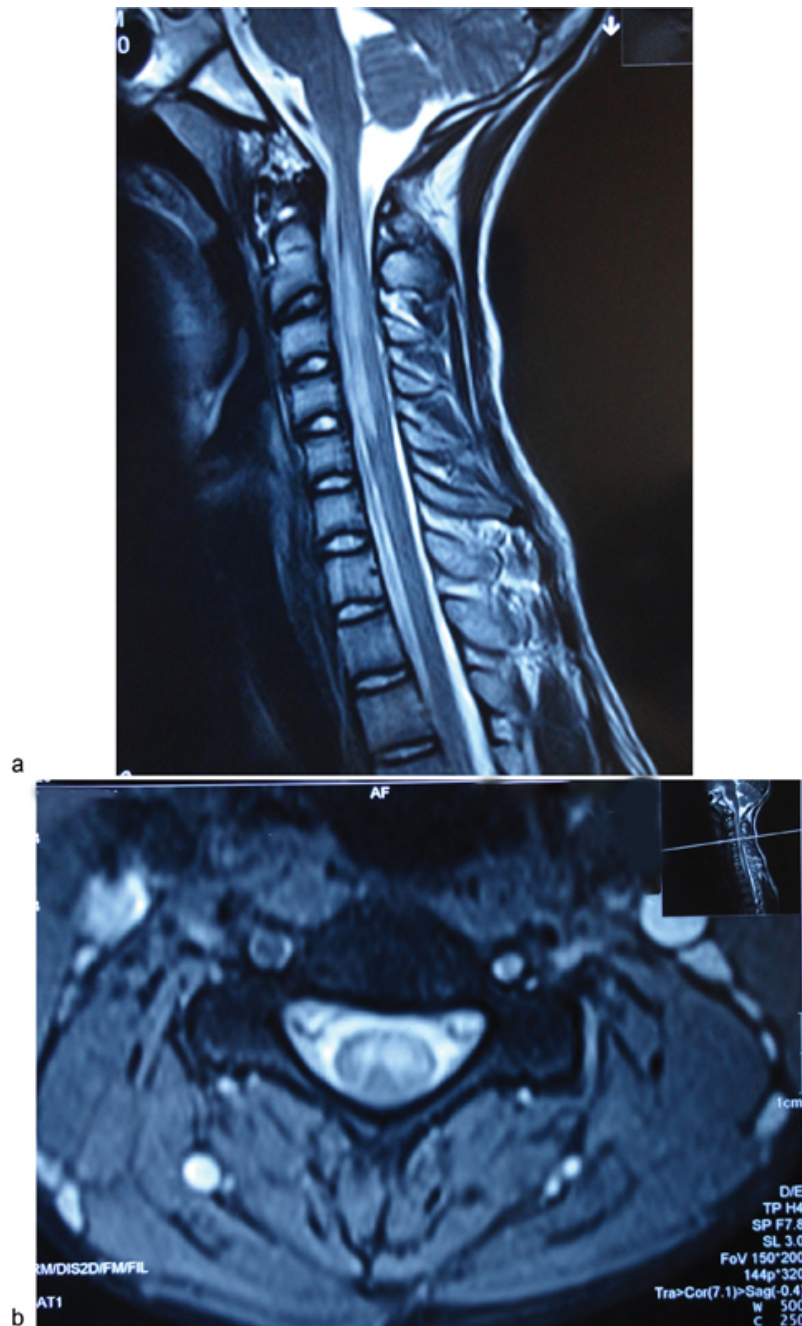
(a) T2 sagittal magnetic resonance imaging (MRI) showing hyperintense signal in the anterior half of the cord extending from C1 to C5 with cord swelling. (b) T2 axial MRI showing hyperintense signal in the anterior half of the cord.
